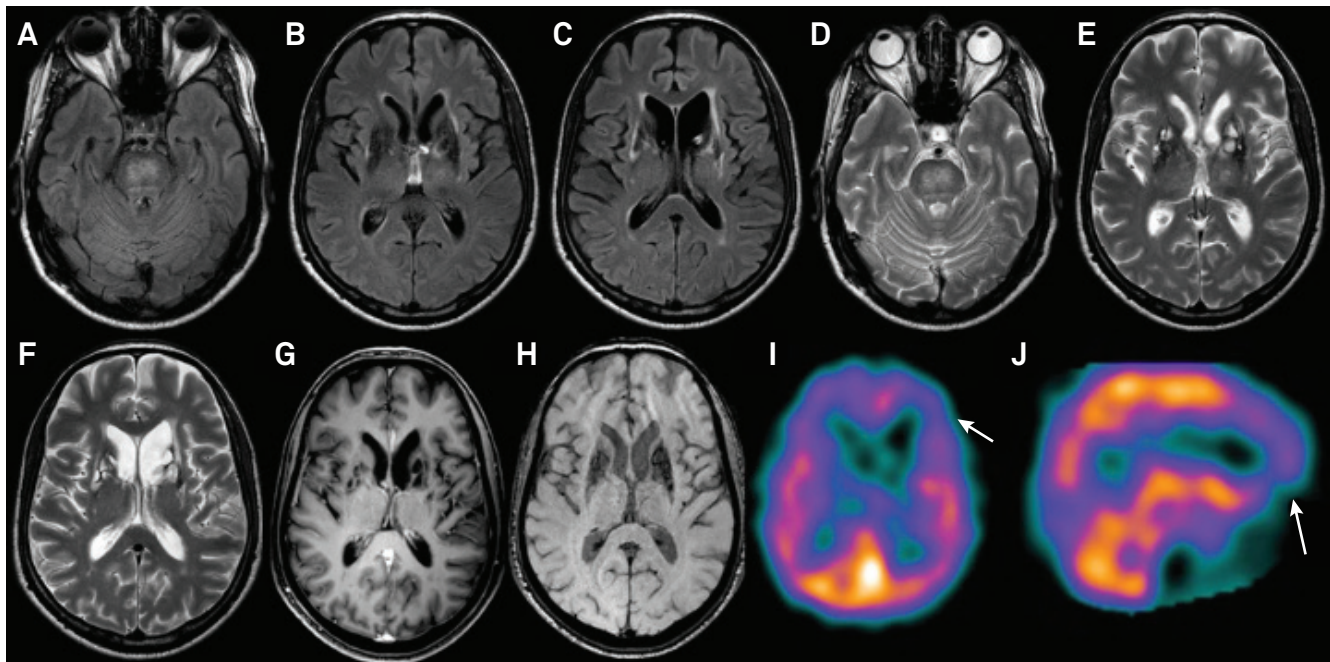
Neuroimaging findings in pseudoxanthoma elasticum. Axial brain MR imaging showing multiple pontine and bilateral basal ganglia lacunar infarcts with iron deposition in FLAIR sequence (A-C), T2-weighted imaging (D-F), T1-weighted imaging (G) and SWI sequences (H). (I,J) Brain Tc-99m SPECT disclosing bilateral frontal hypoperfusion (white arrows).
